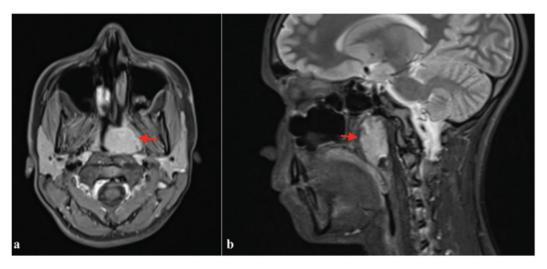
Corrected MRI scan reveals a 3×2.5×2 cm lobulated, expansile, nasopharyngeal mass which obliterates the nasopharynx and extends into the left Rosenmüller fossa *MRI: Magnetic resonance imaging*
